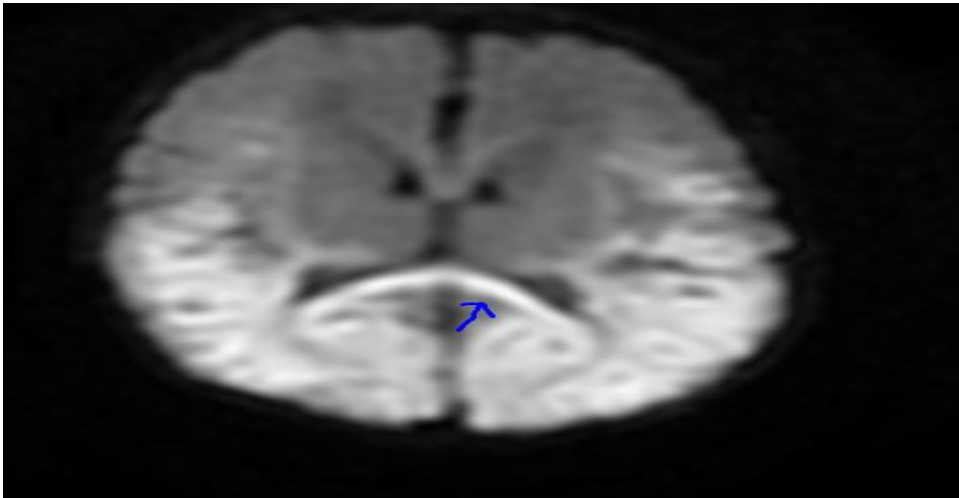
Axial Diffusion Weighted Image of Brain MRI: Bilateral parietal-occipital cortex with Corpus callosum abnormalities in term neonate with Hypoglycaemic Brain Injury. Arrow head suggest corpus callosum abnormality.
